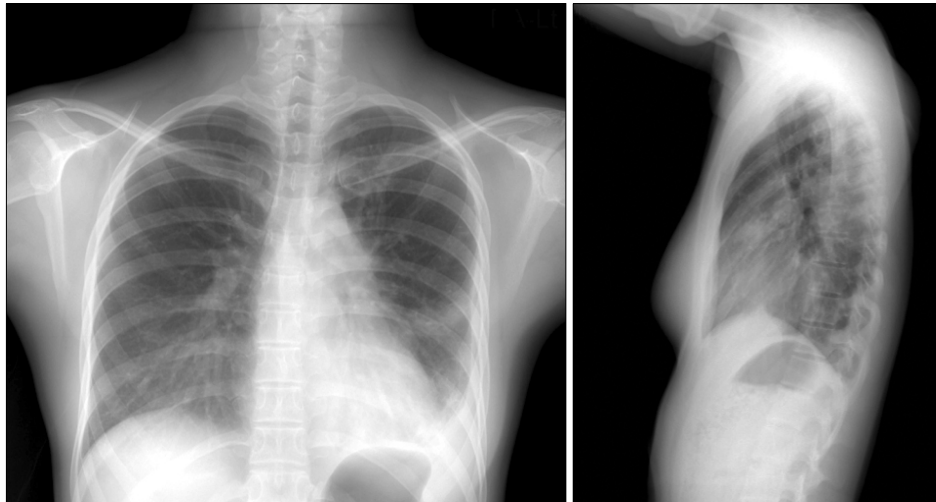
8 months after anti-TB medication, Chest PA and lateral radiography shows newly developed pleural effusion at left hemithorax.
